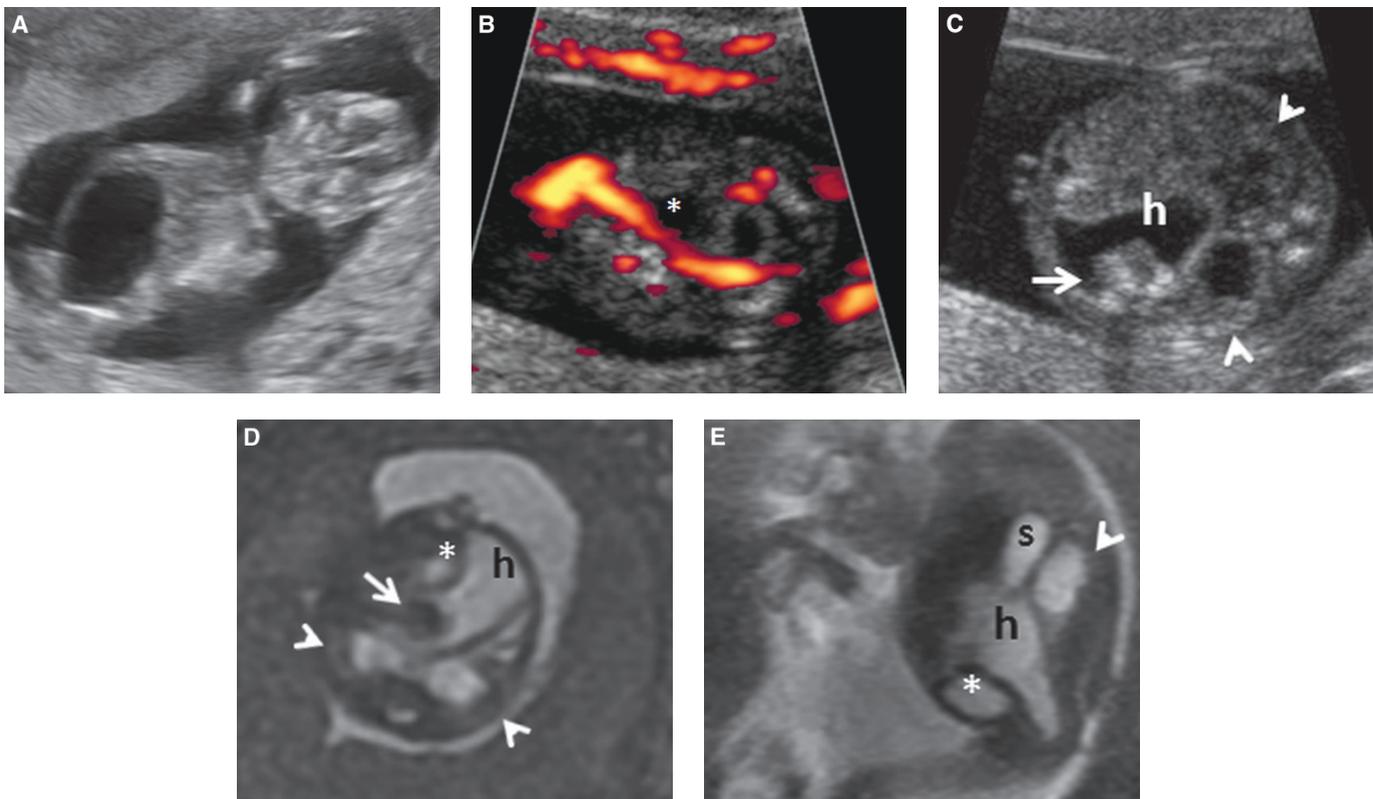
Cloacal malformation with hydrocolpos. A: Coronal US scan at 13 weeks GA shows a large abdominopelvic cyst. Axial US (B), axial 2D SSFP and sagittal fetography (C) fetal MRI sequences on same fetus at 17w GA. There is bilateral hydronephrosis, large hydrocolpos (*h*) containing intraluminal echogenic foci with posterior shadowing (*arrow* on C) or dark T2 material as expected for meconium (*arrow* on D). The bladder is anterior to the hydrocolpos (*asterisk*) and the stomach (*s*) anterior to the left kidney (*arrowhead* on E).
